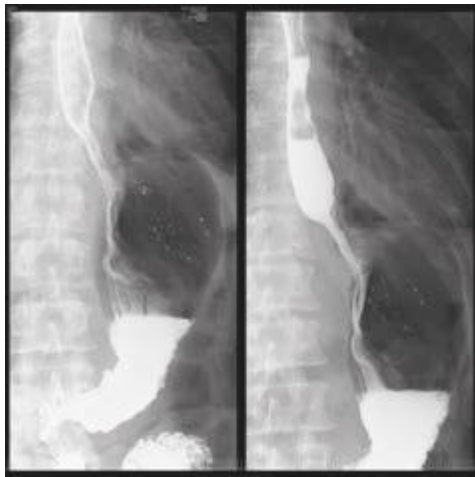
X-ray contrast study of the esophagus and stomach on the 20th day after surgery
